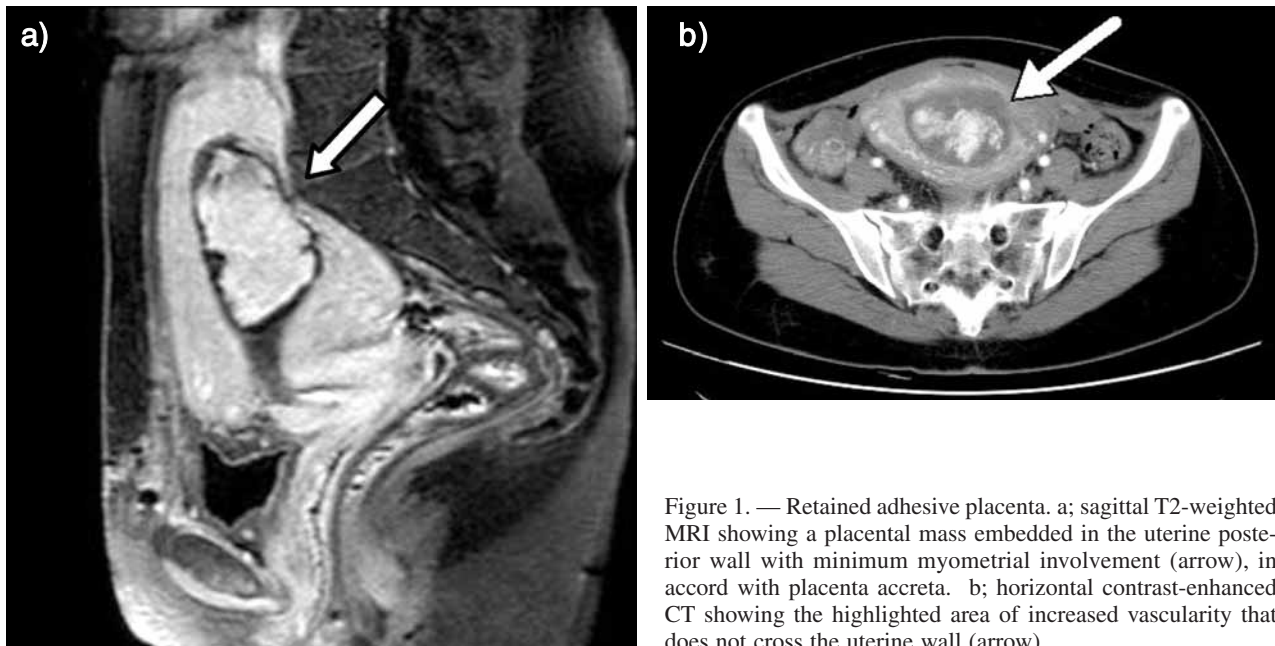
Retained adhesive placenta. a; sagittal T2-weighted MRI showing a placental mass embedded in the uterine posterior wall with minimum myometrial involvement (arrow), in accord with placenta accreta. b; horizontal contrast-enhanced CT showing the highlighted area of increased vascularity that does not cross the uterine wall (arrow).
